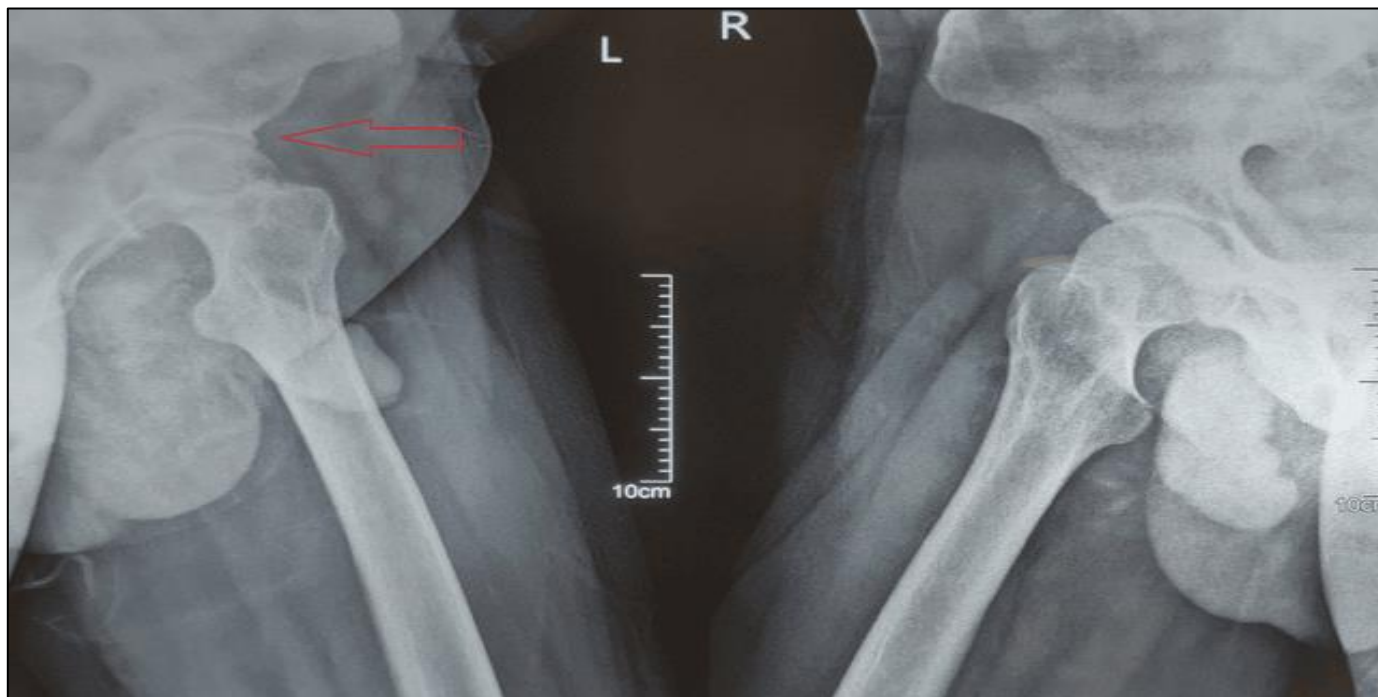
X-Ray of Pelvis (Anteroposterior View)
